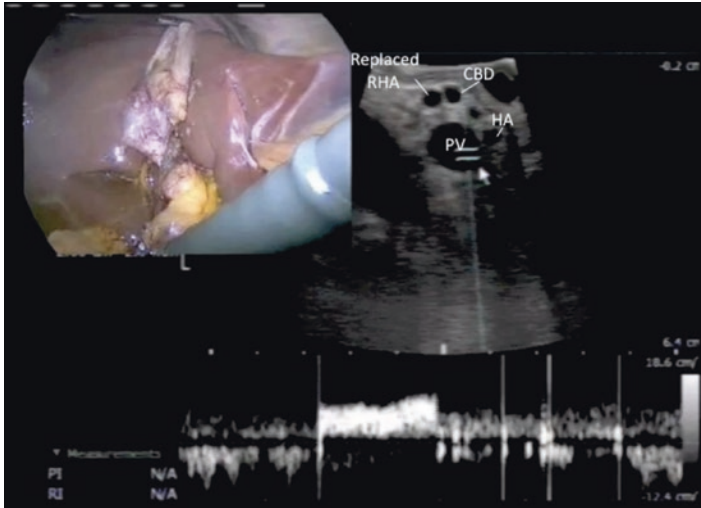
Hepatic vascular anatomical variation is identified in approximately 15% of patients at biliary ultrasonography. This image demonstrates replaced right hepatic artery at the level of the porta hepatis. *RHA* replaced right hepatic artery
